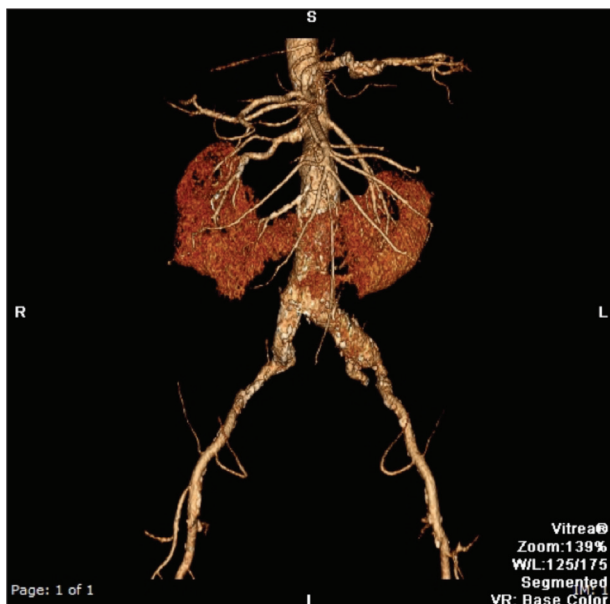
Preoperative CT three-dimensional reconstruction shows a 6.1-cm AAA, a 25-mm LCIA aneurysm, and HSK morphology.
